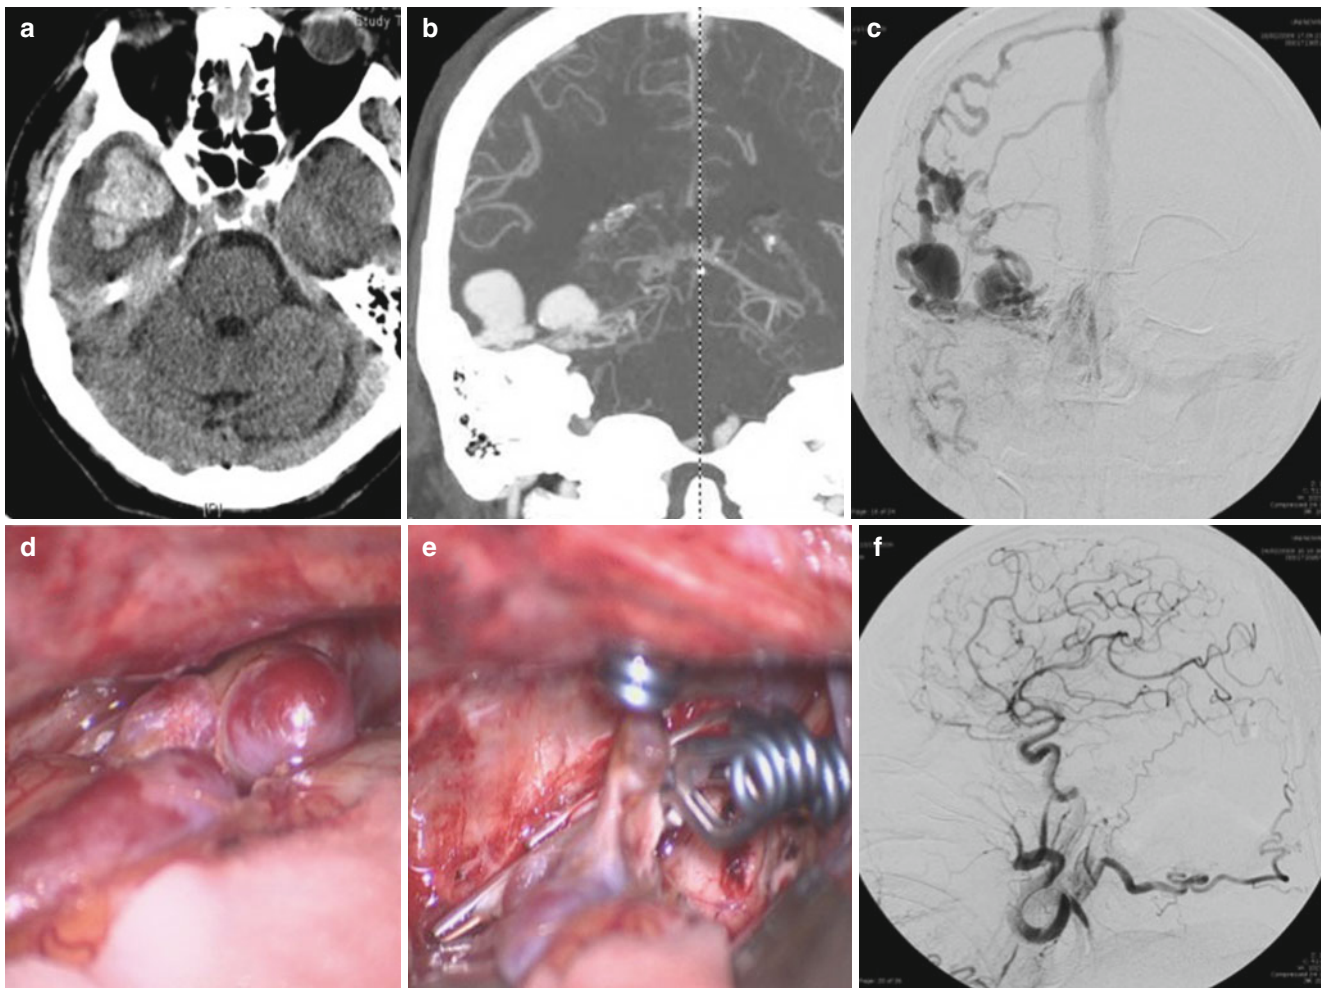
(a) Basal CT scan of a patient suffering from sudden headache shows the presence of a right temporal intraparenchymal hemorrhage. (b, c) CT-angiography and DSA document the presence of a Type IV temporobasal fistula. (d, e) Intraoperative picture showing the venous ectasias and the multiple clippings of dilated veins of the fistula. (f) Postoperative DSA confirming the fistula exclusion
